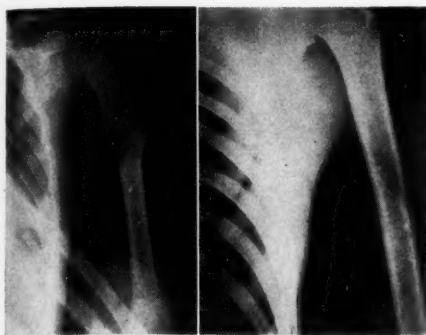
Case 12: Giant-cell tumor of upper third of left humerus. Left: Status after curettage and before roentgen therapy. Right: Eleven years later.
